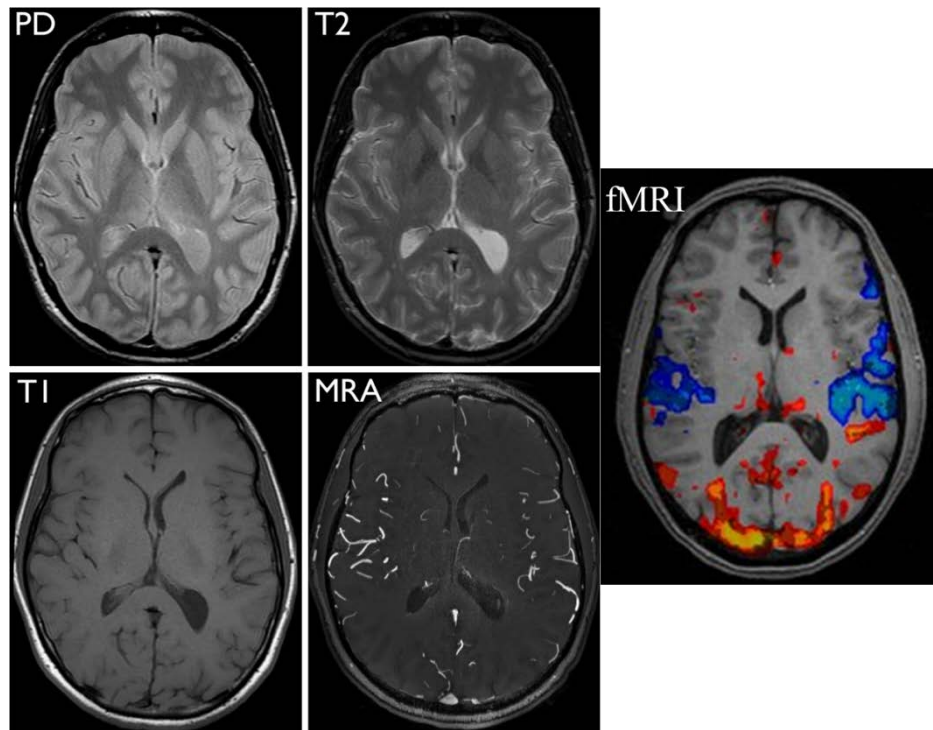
Normal human brain images using different MRI modalities (Image sources:
